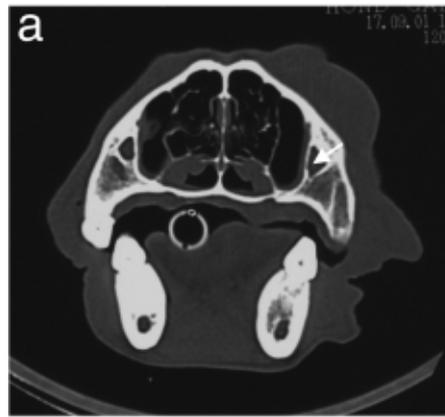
a: Computed tomographic bone window image of patient 15. An extensive soft tissue mass is evident on the dorsal and lateral aspect of the left maxilla, fairly caudally at the level of the nasopharyngeal opening (1) and the maxillary recess (arrow). Note that the soft tissue margins are poorly defined although grossly visible. Diagnosis: fibrosarcoma.
